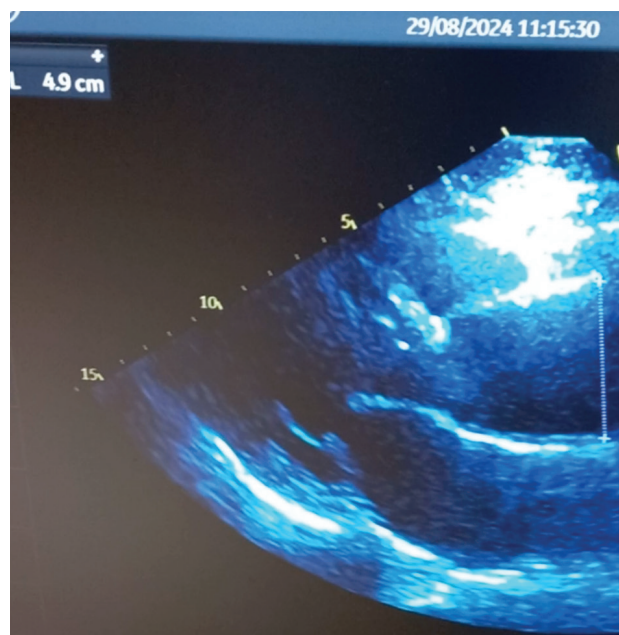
Ascending aorta dilatation with no signs of intimal flap in the left parasternal long axis view on transthoracic echocardiogram.
